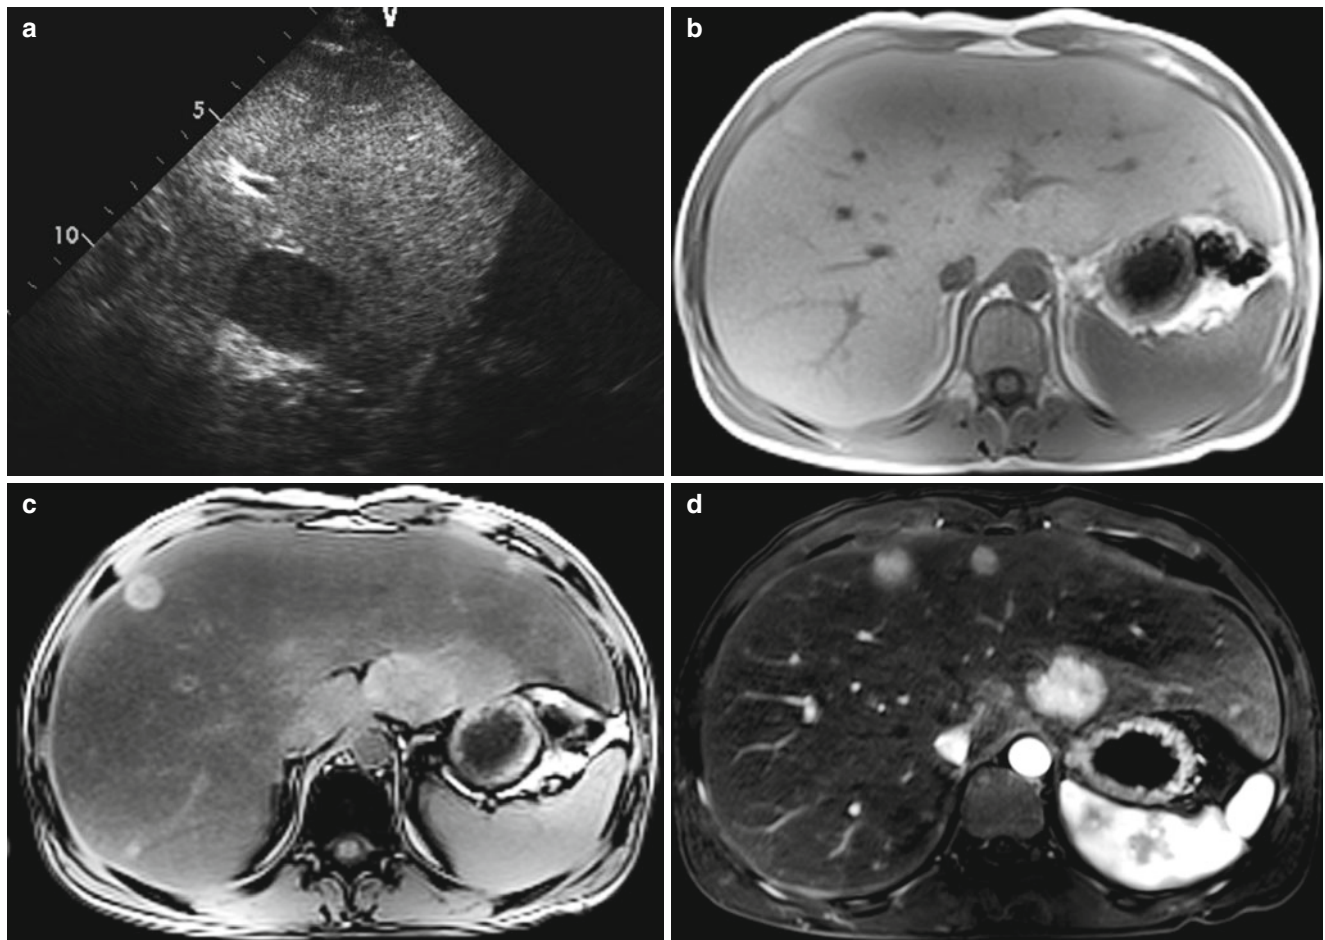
Glycogen storage disease type I with multiple hepatic adenomas in a 19-year-old male. (a) Hypoechoic hepatic mass was incidentally found with diffusely increased liver parenchymal echogenicity during echocardiography. (b and c) Axial T1-weighted gradient echo
